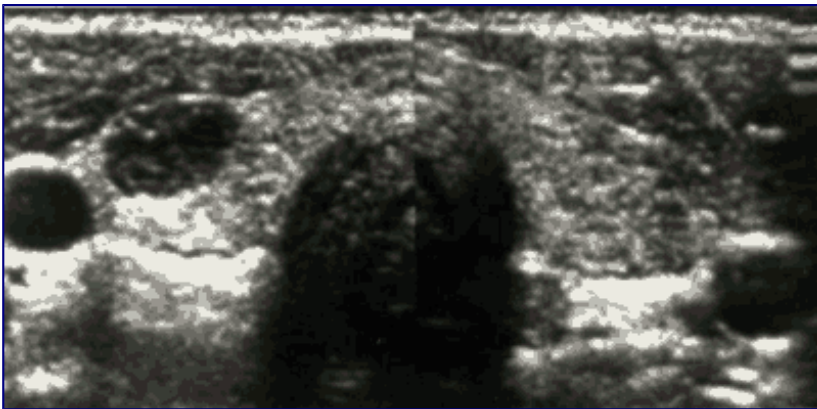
Ultrasooigraphic examination by transverse image of the thyroid containing a solid nodule in the right lobe and a homogeneous appearance of the left lobe. The structure peripheral to the nodule is the internal jugular vein.
